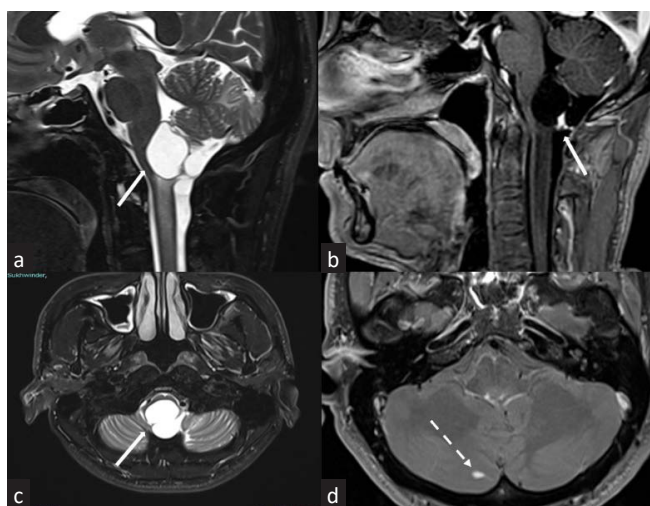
MRI images of brain and cervical spine of a 34-year-old man with VHL. (a-c) Sagittal and axial T2 weighted and postcontrast images reveal a well-defined T2 hyperintense cystic lesion with hyperenhancing mural nodule within the dorsal aspect of the medulla: hemangioblastoma (solid white arrows). (d) Axial postcontrast images show a small intensely enhancing area in the right cerebellar hemisphere: cerebellar hemangioblastoma (dashed white arrow). VHL: Von-Hippel-Lindau, MRI: Magnetic resonance imaging.
